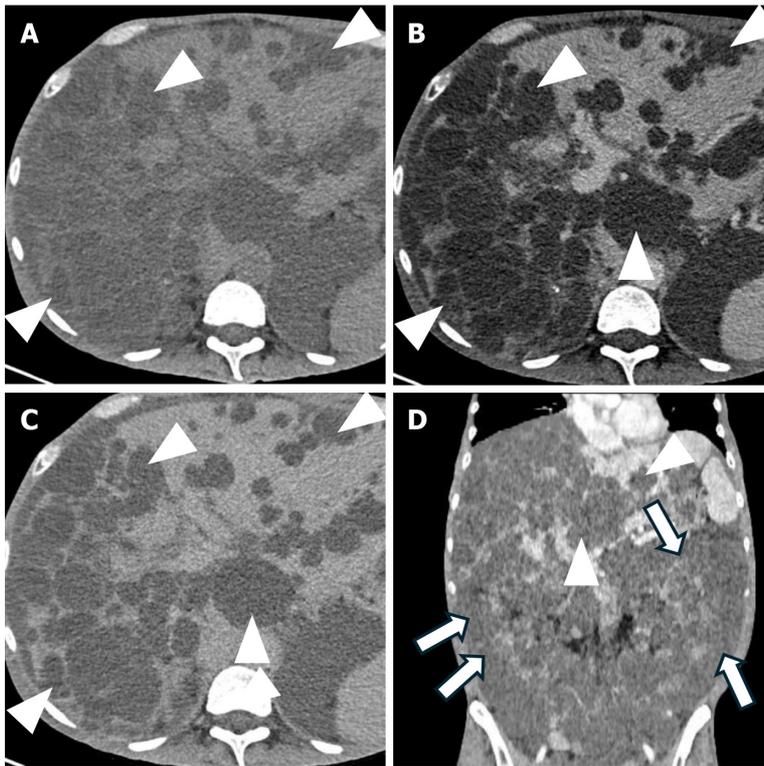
Polycystic liver disease. A: Axial non-contrast computed tomography (CT) image demonstrates multiple hypodense lesions (arrowheads); B: Axial contrast-enhanced CT image in the portal venous phase shows multiple hypodense lesions with no enhancement (arrowheads); C: Axial contrast-enhanced CT image in the delayed phase demonstrates multiple hypodense lesions with no enhancement (arrowheads); D: Coronal contrast-enhanced CT image in the portal venous phase shows multiple hepatic (arrowheads) and renal (arrows) cysts.
